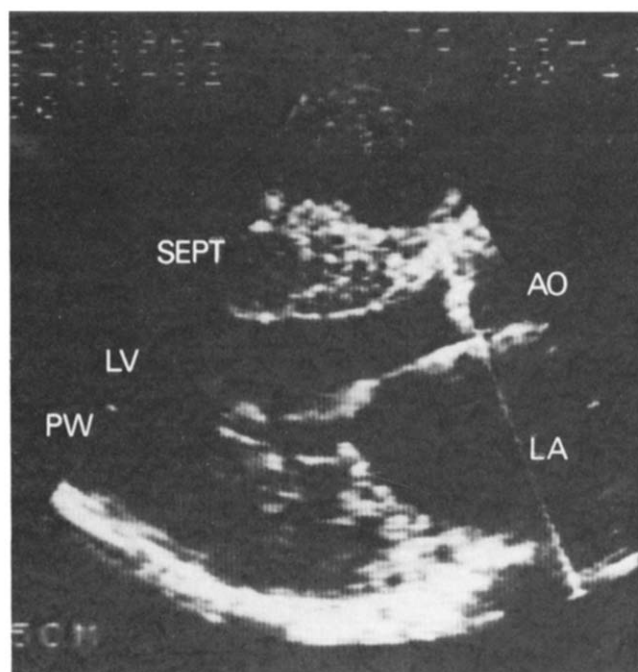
Parasternal long-axis view of two-dimensional echocardiogram in a typical case of cardiac amyloidosis (early diastole). The septum (SEPT) and posterior wall (PW) are thickened with the classic increased echogenicity seen with amyloid infiltration. The cursor passes through a thickened aortic valve. Left ventricular (LV) cavity size is normal. AO = aorta, LA = left atrium.
